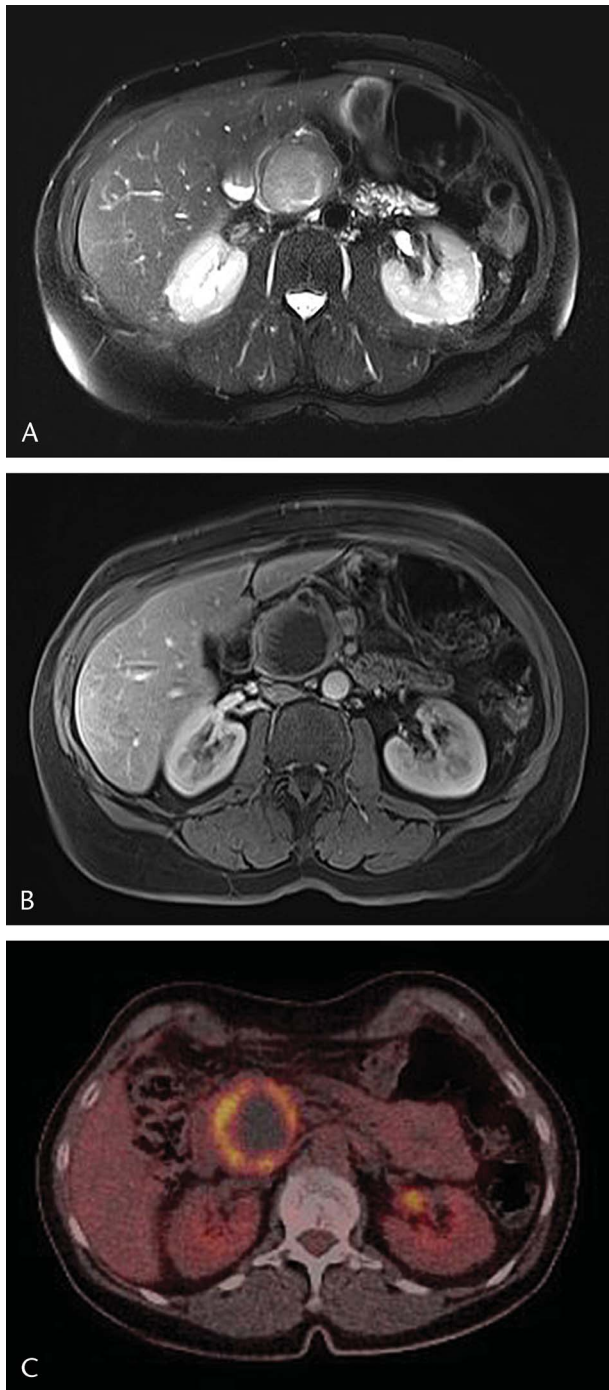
Axial T2-weighted MR image (half-Fourier acquisition single-shot turbo spin echo [HASTE]) with a sharply demarcated high signal intensity mass (45 mm) in the pancreatic head (A). Axial T1-weighted image (T1 volumetric interpolated breath-hold examination [T1-VIBE]) with fat suppression) after intravenous injection of a contrast agent (gadoterate meglumine) shows enhancement of the wall with some linear papillary projections and a large nonenhancing center, possibly because of necrosis or mucinous component (B). On fluorine-18 fluorodeoxyglucose positron emission tomography (18F-FDG-PET), the wall of the tumor is avid with a large photopenic center (C).
